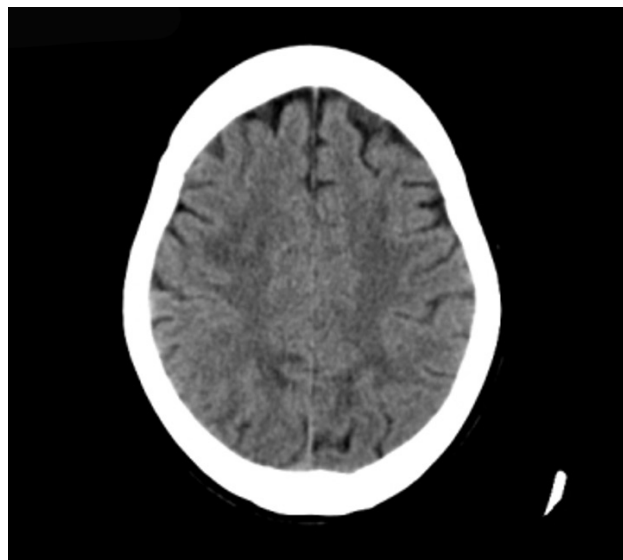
Computed tomography examination showing symmetric bilateral hypodensities predominantly in the occipital lobes and part of the frontal lobes.
